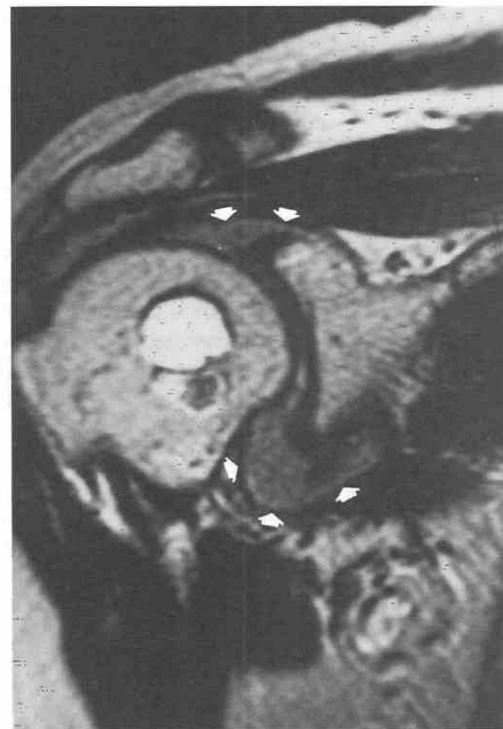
Rheumatoid arthritis. T2-weighted (TR = 2500 msec, TE = 80 msec) coronal oblique MR image. High-signal-intensity and mixed-signal-intensity lesions in the humeral head contact the articular surface in other sections and probably represent deep erosions. Pannus at the periphery of the joint (short arrows) is lower in signal than the usual joint fluid and is slightly heterogeneous in signal.
